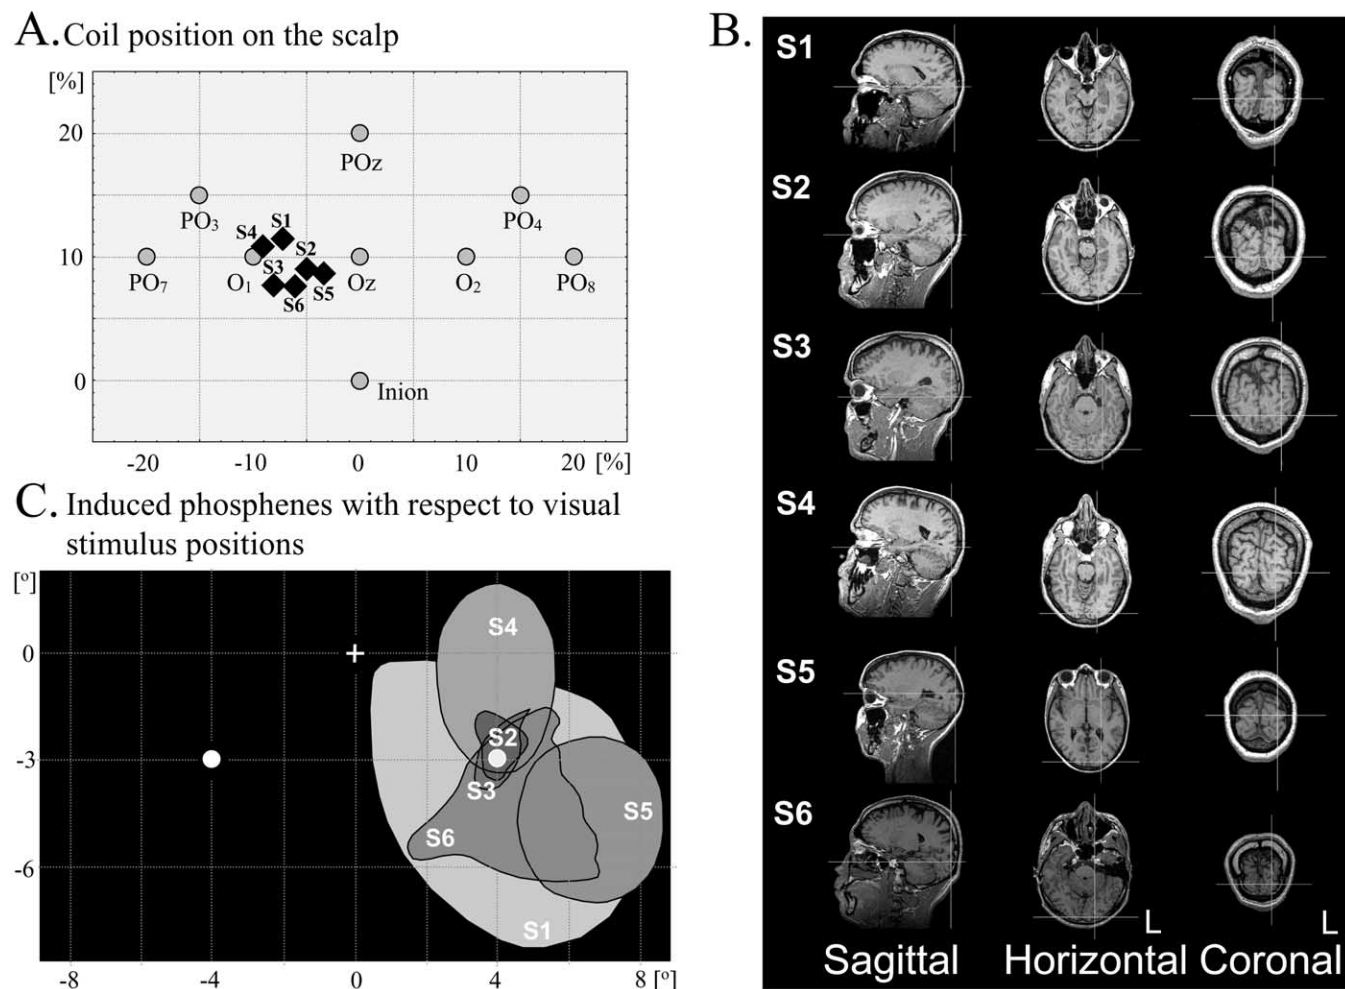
Coil position and induced phosphenes. (A) Location of the coil center relative to occipital electrode positions of the international 10-10 EEG system. Coil locations are represented for each subject separately (S1–S6). (B) Magnetic stimulation site relative to each subject's MR image. TMS sites, extrapolated using a frameless stereotaxic system, are highlighted by cross-hairs. (C) Induced phosphenes as drawn by each subject superimposed on visual stimuli and fixation cross. Phosphenes were induced in the blindfolded subjects by single TMS pulses for optimization of coil positions prior to the experiment. Phosphenes overlap with scotomas (visual suppression) and thus can serve for functional coil positioning to maximize TMS effects on visual functions. Note the overlap of phosphenes with the RVF stimulus. Note also that, as a consequence, one expects rTMS effects to occur mainly in response to RVF stimulation. Data for right hand blocks are presented. There was no difference, neither quantitatively (coil position) nor qualitatively (phosphenes), from the left hand blocks (see Results).
